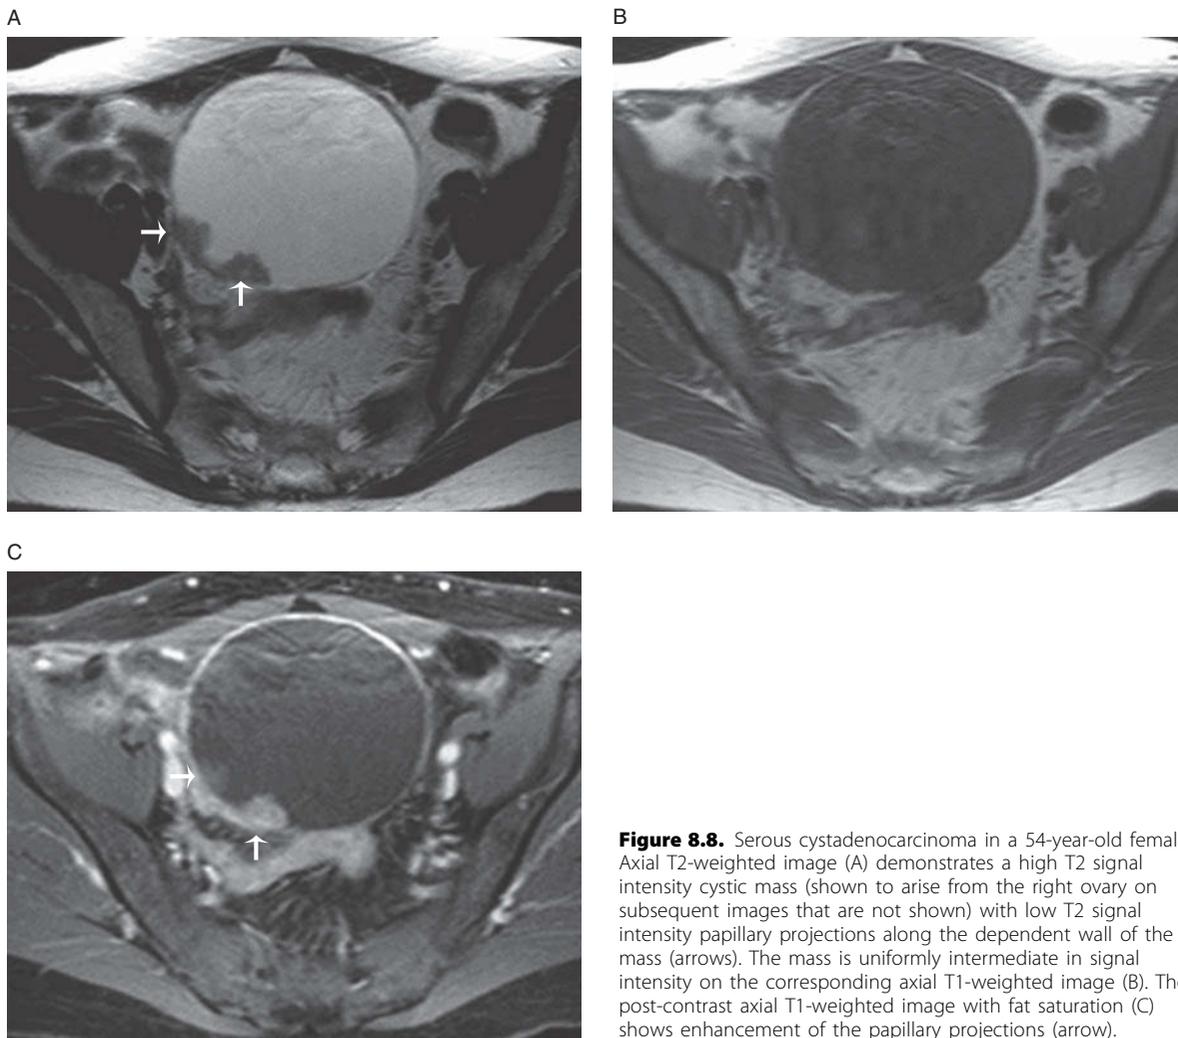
Serous cystadenocarcinoma in a 54-year-old female. Axial T2-weighted image (A) demonstrates a high T2 signal intensity cystic mass (shown to arise from the right ovary on subsequent images that are not shown) with low T2 signal intensity papillary projections along the dependent wall of the mass (arrows). The mass is uniformly intermediate in signal intensity on the corresponding axial T1-weighted image (B). The post-contrast axial T1-weighted image with fat saturation (C) shows enhancement of the papillary projections (arrow).
